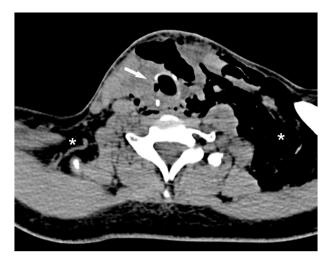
Postoperative enhanced CT scan revealed a tracheal injury (white arrow) with a noticeable bilateral subcutaneous laterocervical and supraclavicular emphysema, prevalent on the left side (white asterisks).
